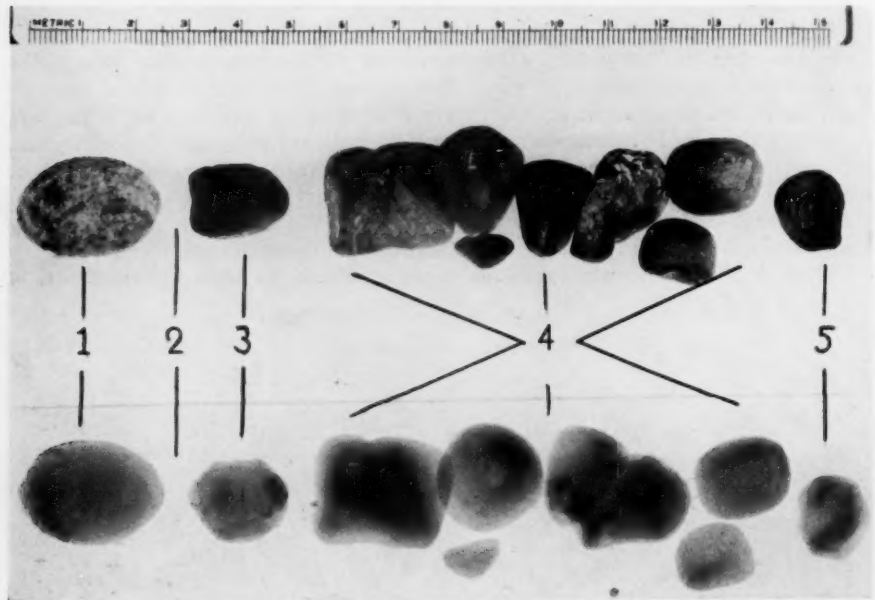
Case 9: Photograph above and roentgenogram below. Stone removed from gallbladder (1). Cholecystectomy in interval (2). Stone removed from common duct at third operation (3); fourth operation (4); and fifth operation (5).
